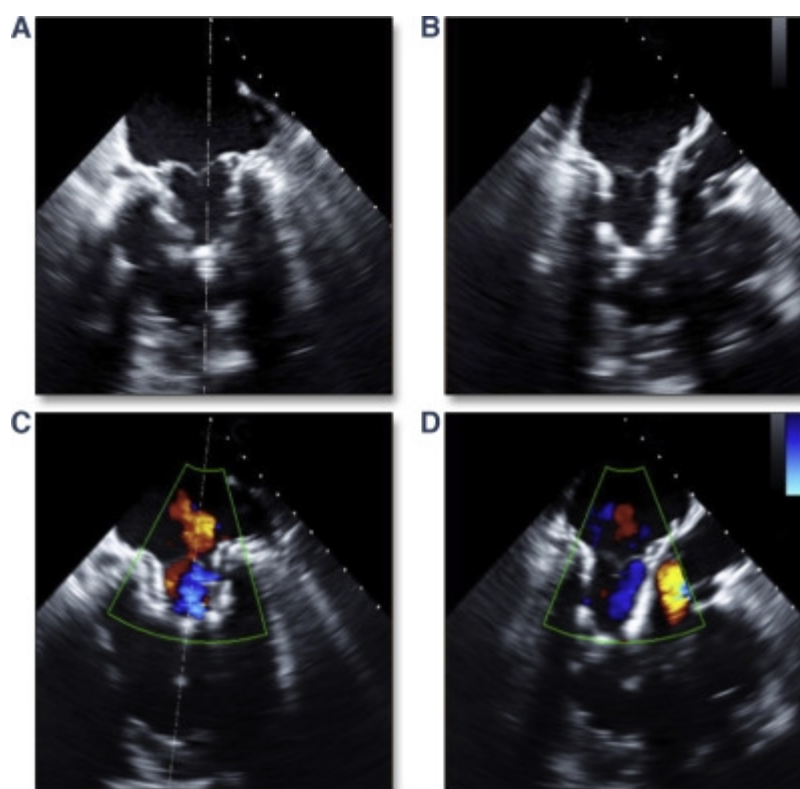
TEE Images Immediately After Implantation of Tendyne Valve. X-plane view shows mid-commissural (A) and long-axis (B) views. Valve leaflets are in closed position (mid-systole). Color Doppler images in same views showing LVOT preservation and no paravalvular leakage (C and D) (Blanke et al., 2015).
